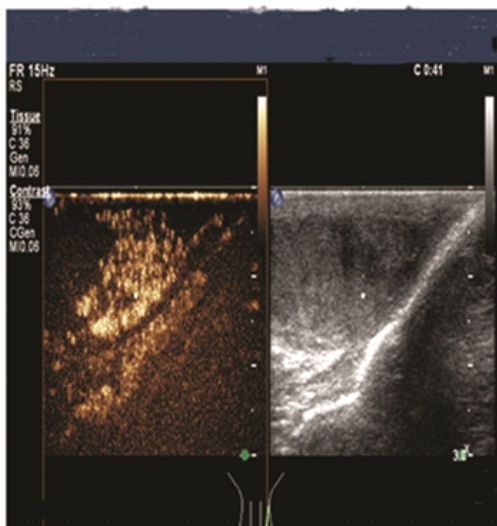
Testicular NK/T cell lymphoma shows a clear hyper-enhancement in CEUS (left) but not in color-coded sonography (right).
